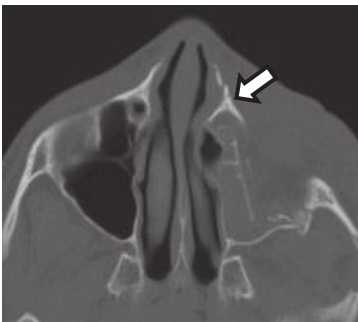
Nasoorbital ethmoid fracture seen on axial CT image. Axial views typically show splaying of the medial vertical maxillary buttress (*arrow*), which appears as an inverted Y. The vertical segment of the inverted Y represents the nasomaxillary buttress, and the anterior and posterior lacrimal crests form the two limbs of the inverted Y.
